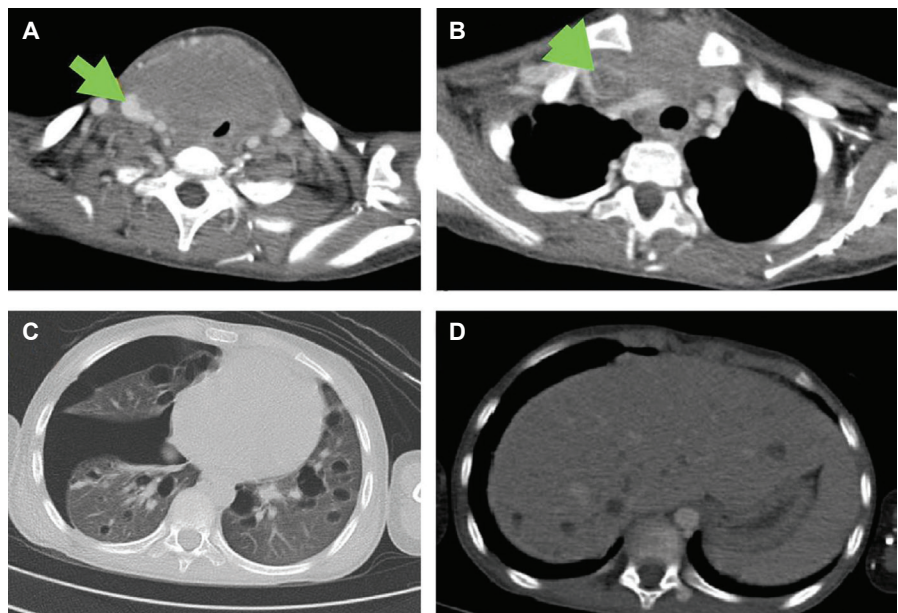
CT scan showing a heterogeneously large lesion replacing the normal looking thyroid lobes. The mass exhibits encroachment to the adjacent jugular veins (A) as well as the SVC (B). There is also a pneumothorax along with multiple pulmonary bleb and bullae with thin septations (C) and hepatomegaly with multiple cysts (D).
